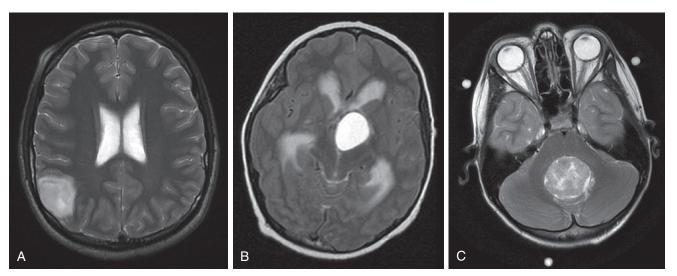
A, Axial T₂ magnetic resonance imaging (MRI) of a child with astrocytoma. B, Axial T₂ MRI of a child with craniopharyngioma. C, Axial T₂ MRI of a child with medulloblastoma.
